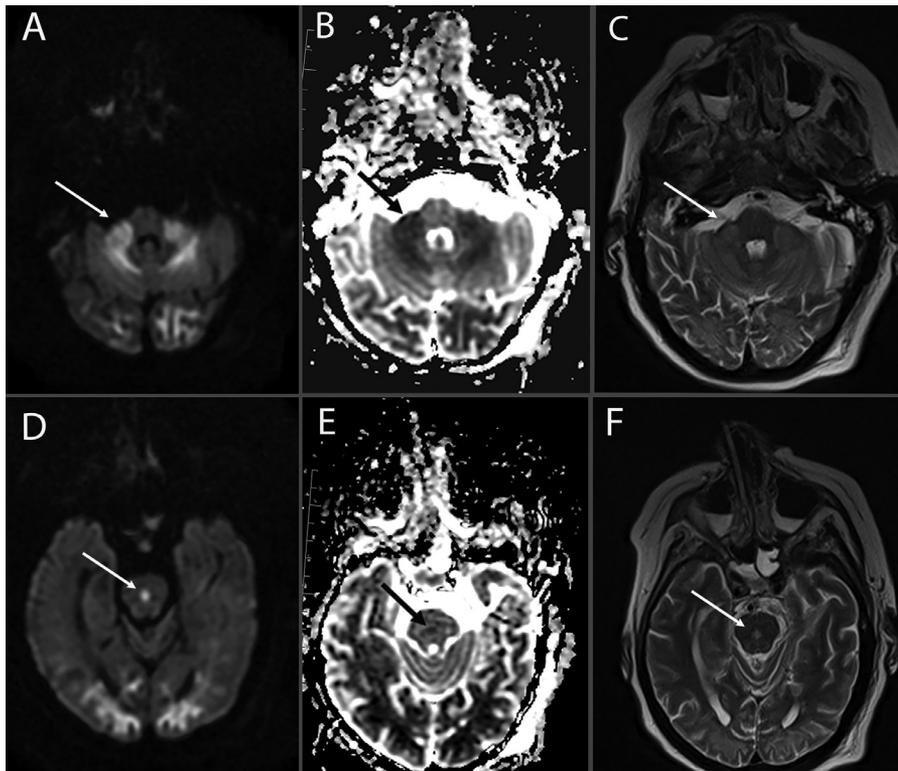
Encephalitis: Acutely ill 60-year-old female with known COVID-19, presents with worsening headache, progressing weakness, seizure and mental status changes. Axial MRI images include (A) Diffusion weighted image (DWI); (B) Apparent diffusion coefficient (ADC); and (C) T2-weighted image through the level of the middle cerebellar peduncles (arrows) showing bilateral, symmetric edema and diffusion restriction consistent with acute inflammation expected with viral encephalitis. (D) DWI; (E) ADC and (F) T2-weighted MRI images through the level of the pons demonstrate both pontine (arrows) and bilateral occipital lobe signal abnormality as described in A-C above. This patient did not demonstrate hemorrhage, or enhancement, which can be present to varying degrees in viral encephalitides. Work up for other infectious agents was negative. Given known COVID diagnosis and eventual precipitous demise, the presumptive diagnosis of COVID-associated encephalitis was ascribed. *Images courtesy of Dr. David D. Pasquale, MD.
